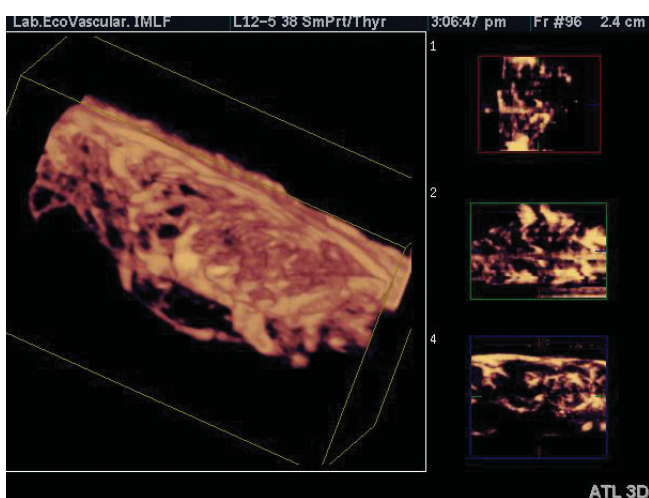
3D vascular ultrasound showing sub-acute thyroiditis
